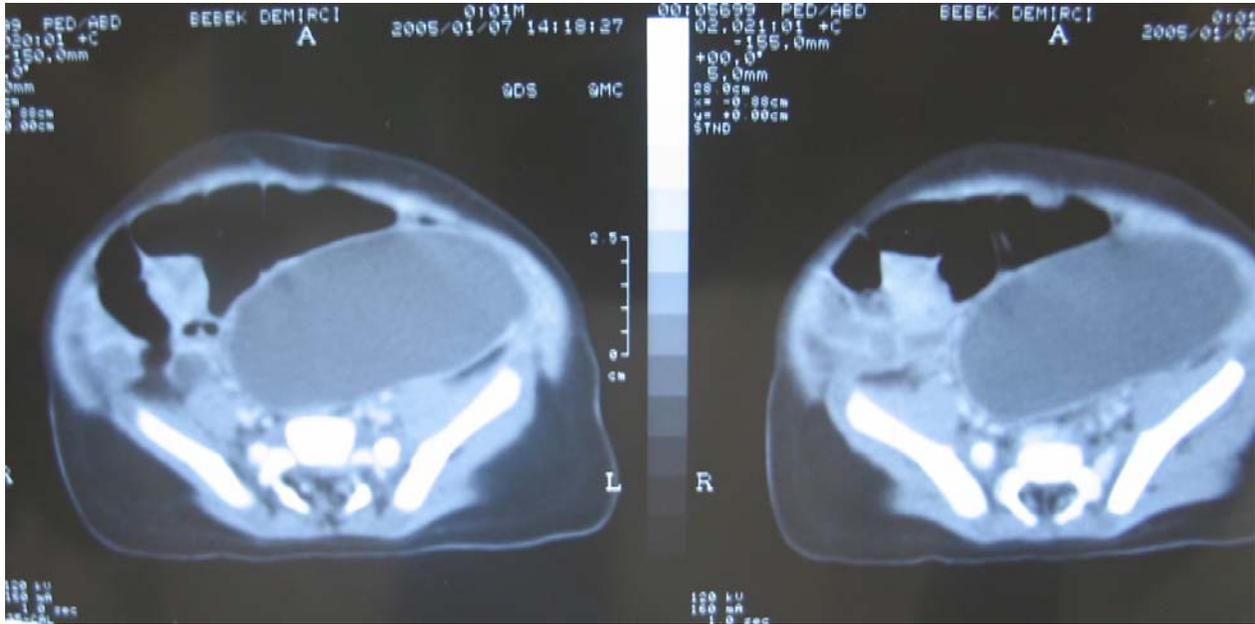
Computed tomography scan shows an extremely cystic mass in the abdomen.
